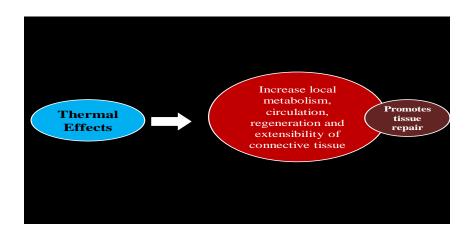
Mechanism of action of Therapeutic Ultrasound
